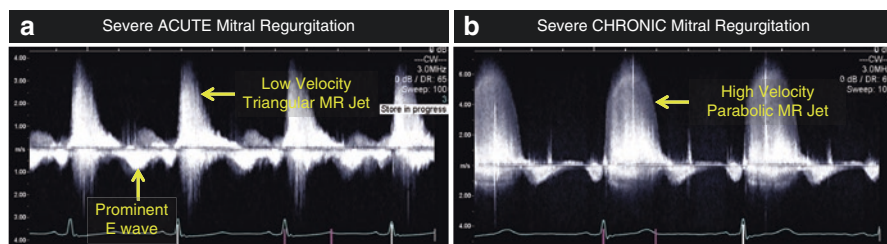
Acute vs. chronic MR on spectral Doppler. Panel (a): Continuous-wave Doppler across the mitral valve in severe acute mitral regurgitation. Note that the low-velocity, rapidly dissipating LV to LA systolic gradient may result in a soft or even absent mitral regurgitation murmur. Panel (b): Continuous-wave Doppler across the mitral valve in severe chronic mitral regurgitation. *Abbreviations:* E wave early diastolic flow, MR mitral regurgitation
